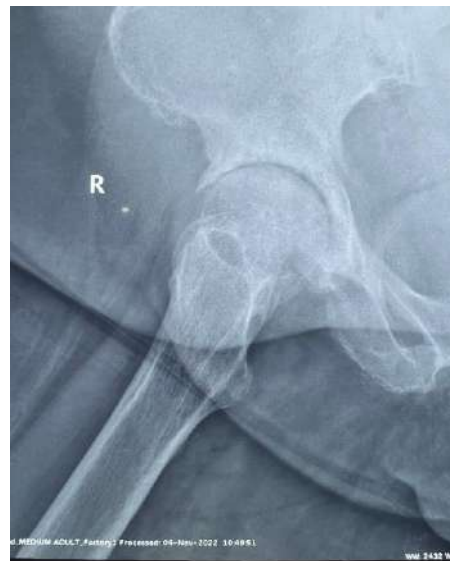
X-ray of the right hip joint 24 months after the procedure (November 2022).
